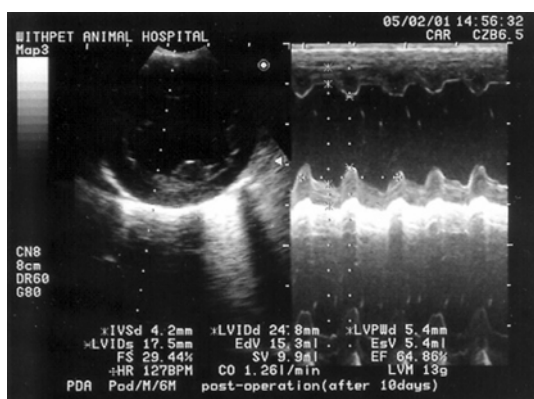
Ultrasonographic finding of 10 days after needle acupuncture.
